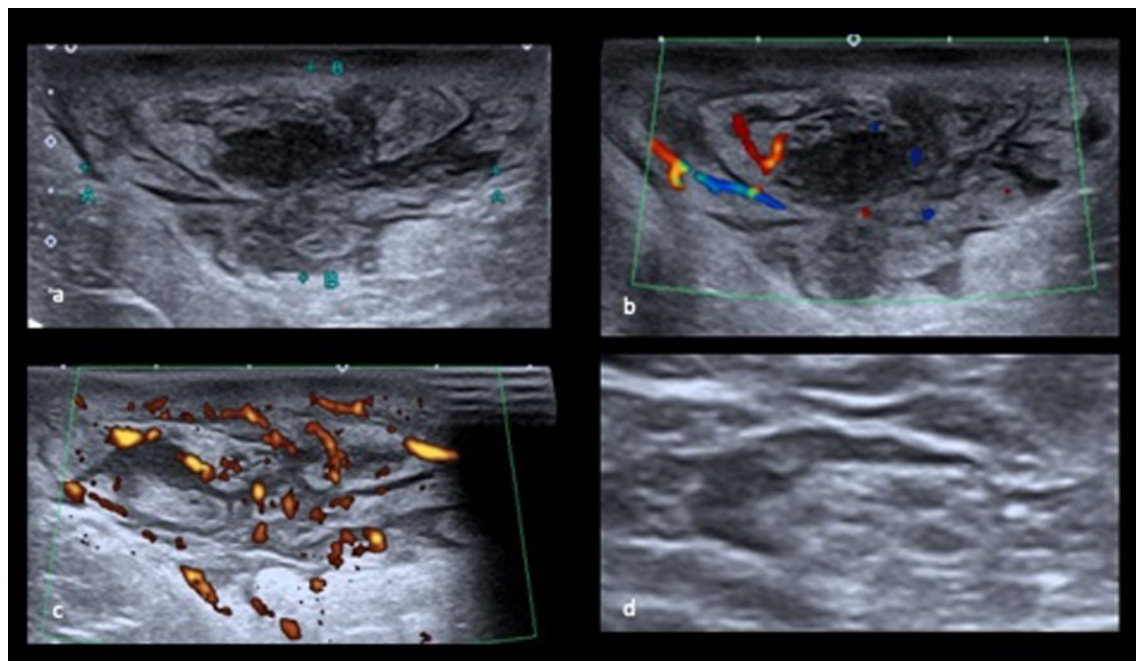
a Grey scale ultrasound of the breast shows a non-circumscribed irregular heteroechoic lesion in subcutaneous plane. The lesion closely abuts the skin with overlying significant skin thickening. b, c Color flow and Doppler ultrasound show avid internal vascularity. d Right axilla ipsilateral axillary lymph nodes with preserved fatty hilum
